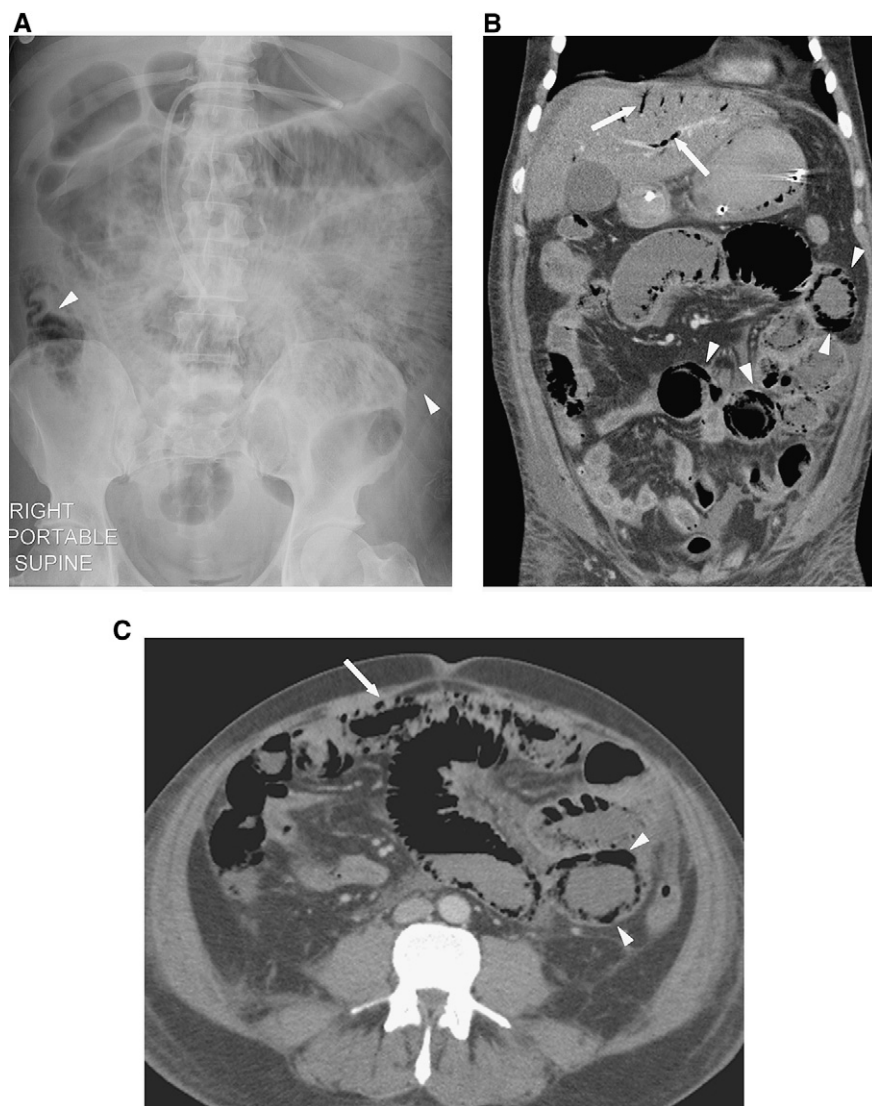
Pneumatosis intestinalis in a patient with Philadelphia chromosome positive acute lymphoblastic leukaemia that presented with febrile neutropenia during induction chemotherapy that included the tyrosine kinase inhibitor imatinib. (A) A plain radiograph of the abdomen, revealing multiple loops of small bowel with linear streaks of air in keeping with bowel pneumatosis (arrowheads). (B) Coronal computed tomographic (CT) abdominal images, depicting pneumatosis intestinalis (arrowheads) and air in the portal venous system (arrows). (C) The axial CT image, revealing pneumatosis intestinalis (arrowheads) with air fissuring through to the serosal surface of bowel wall (arrow).
